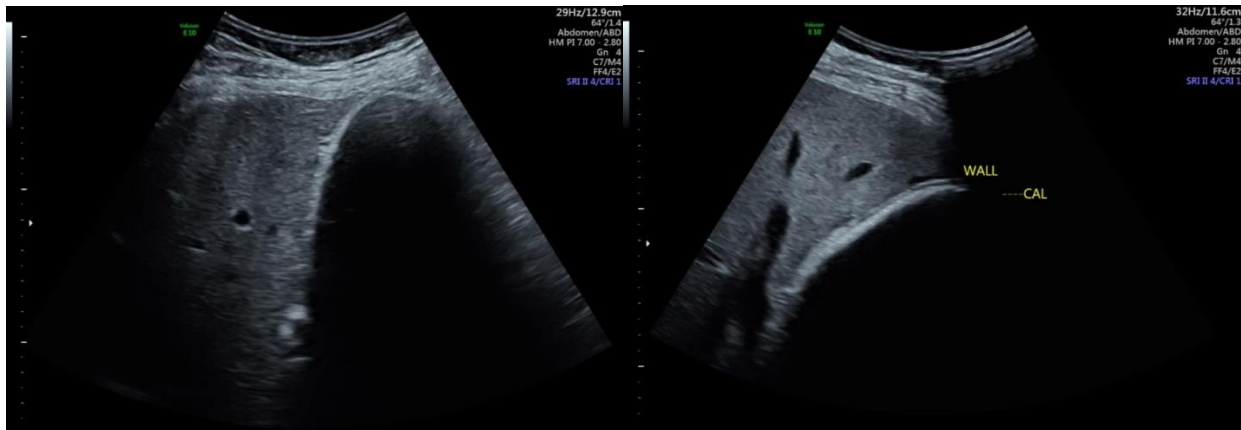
Gallstone noted on Ultrasonography.
